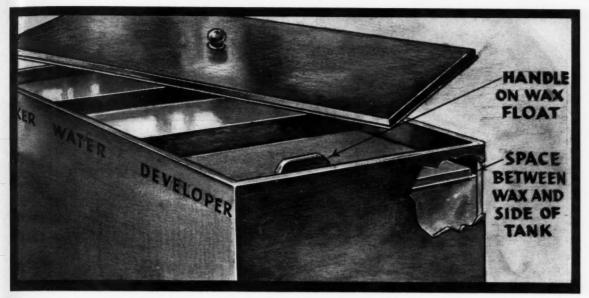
Large x-ray tank in three sections for fixer, water, and developer. Wax float in place on developer.
